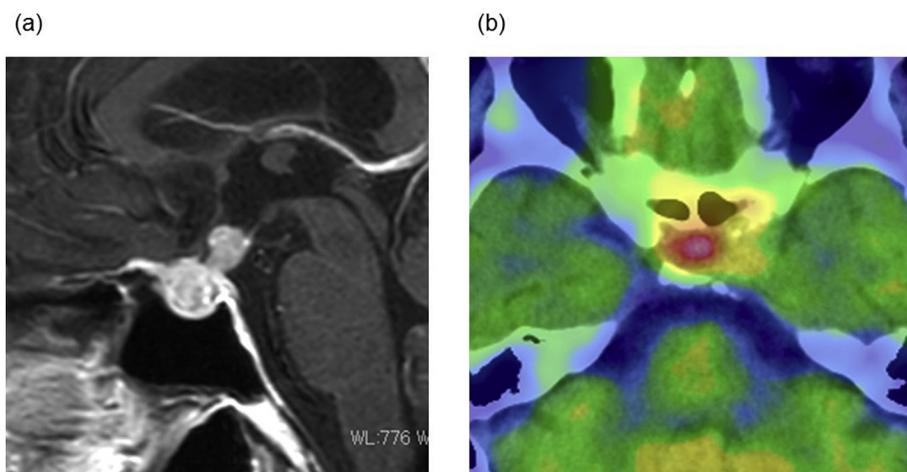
(a) Contrast-enhanced MRI on admission revealed a heterogeneously enhanced lesion in the pituitary with thickened pituitary stalk (b) FDG-PET/CT revealed abnormal accumulation in the pituitary accompanied by osteoclasts.
